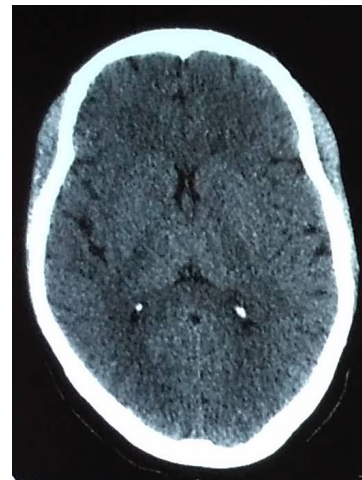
Axial view of a cerebral computed tomography without contrast agent injection showing no signs of acute subarachnoid hemorrhage
